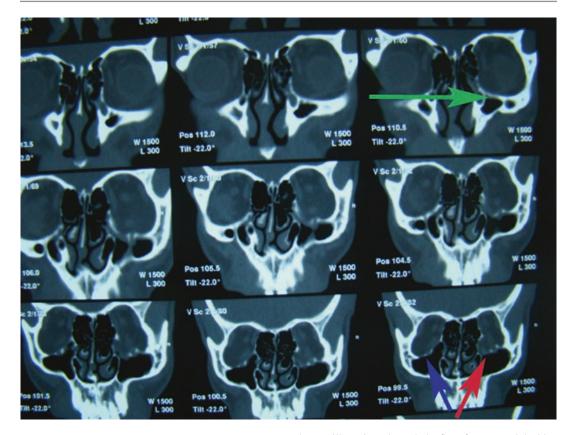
Coronal CT scan showing a 'Blowout' fracture of the orbit. The green arrow shows the intact orbital margin, the red arrow the extrusion of orbital contents into
